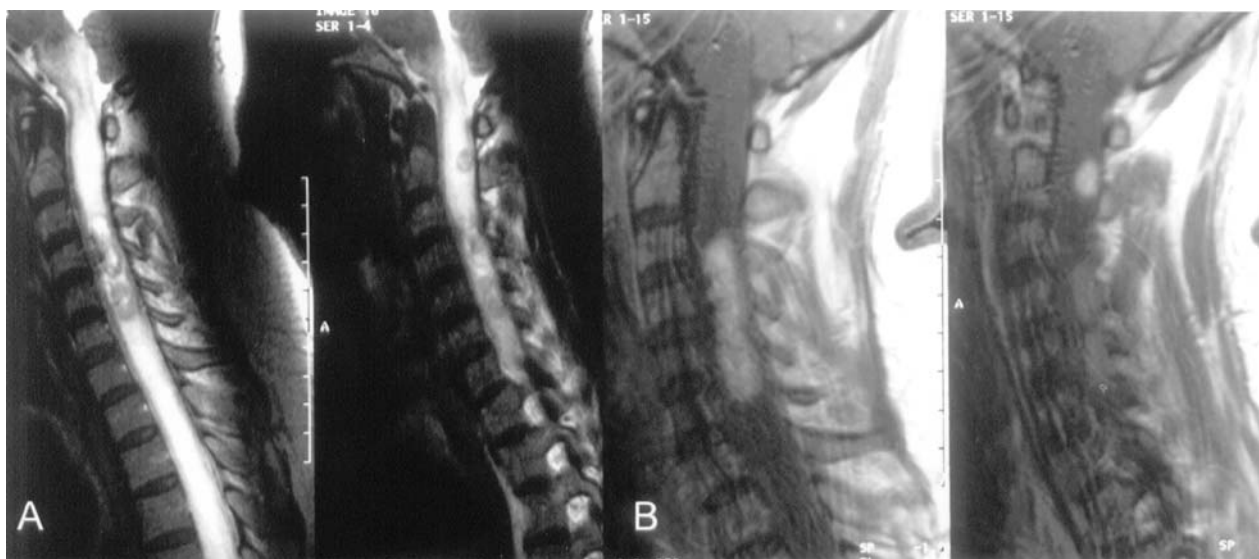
Initial MRI with high signal of medulla oblongata, cervical and upper thoracic spinal cord caused by severe cord swelling (T2-weighted images – A). Delineation of intramedullary haemangioblastomas after contrast (T1-weighted images – B)
